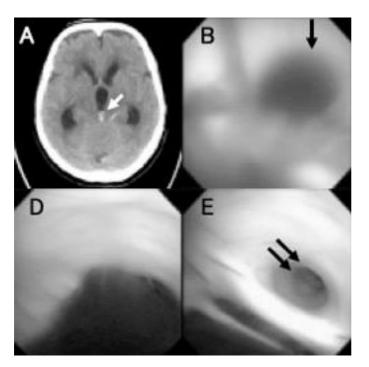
A female patient, 77 years of age, was admitted to our hospital with 168 169 subarachnoid hemorrhage. Endovascular embolization was performed to treat a 170 ruptured dissecting aneurysm of the left posterior inferior cerebral artery. The patient 171 became comatose state on the first postoperative day. A: CT images on acute 172 deterioration showing a clot plugging the cerebral aqueduct (single white arrow) and 173 moderate enlargement of the cerebral ventricle. B: CT images after the procedure 174 showing clot removal and improved cerebral ventricle size. C: As the endoscope 175 approached from the right anterior horn, the size of the foramen of Monro (single 176 black arrow) was not enlarged. D: A red clot plugged into the cerebral aqueduct. E: 177 The clot was removed and a narrow cerebral aqueduct was observed (double black 178 arrow).
